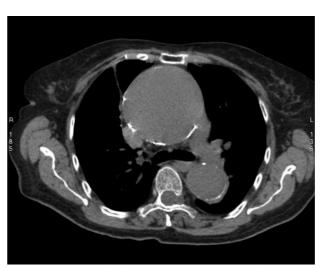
Computed tomography scan (axial view). Giant ascending aortic aneurysm with maximum transverse diameter of 85 mm and calcification of the aortic wall.
